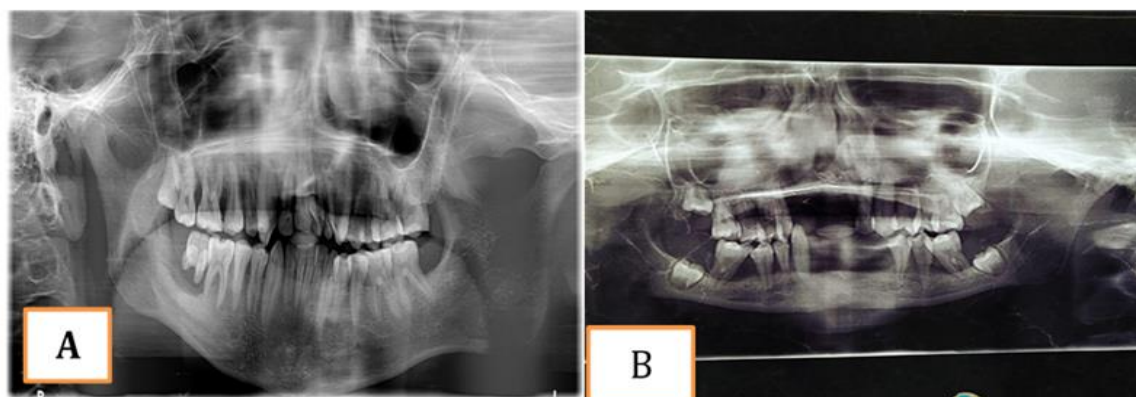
Showing radiographic feature of both [CASE-1; CASE-2] in generalized horizontal bone loss and arc shaped bone loss around lower 1st molar region
